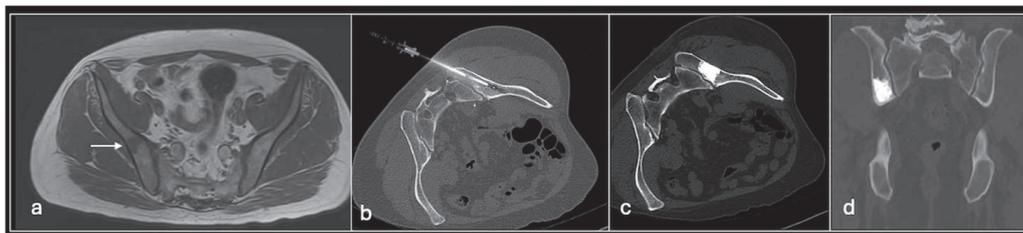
Axial T1 (a) showing metastasis in right ilium (arrow) (b) treated with radiofrequency ablation. Post-cementoplasty axial (c) and coronal (d) CT post-cementoplasty.
